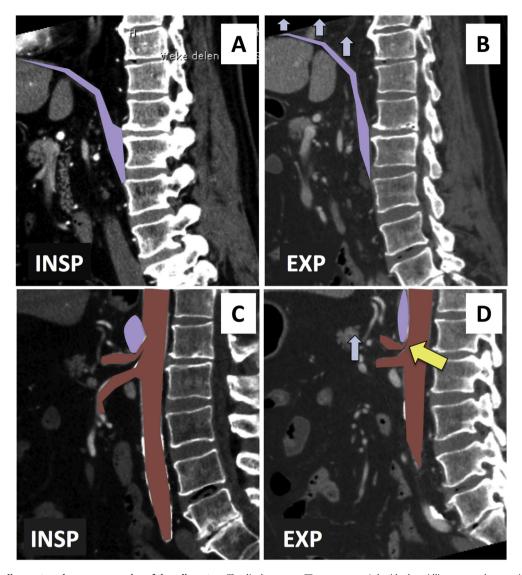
Median arcuate ligament syndrome: compression of the celiac artery. The diaphragm, on CT scan some cm's beside the midline, moves down on inspiration (A) pushing down the abdominal organs. On expiration (B), the abdominal organs move upward. In the midline the effect on the celiac artery can be seen. In this case, the celiac artery is hardly compressed on inspiration (C). On expiration, the celiac artery kinks across the arcuate ligament leading to significant narrowing. Purple: diaphragm. Blue arrows: movement of the diaphragm on. Red: aorta and celiac artery. Yellow arrow: celiac axis compression (from Kolkman et al. PanVascular Medicine [53].
